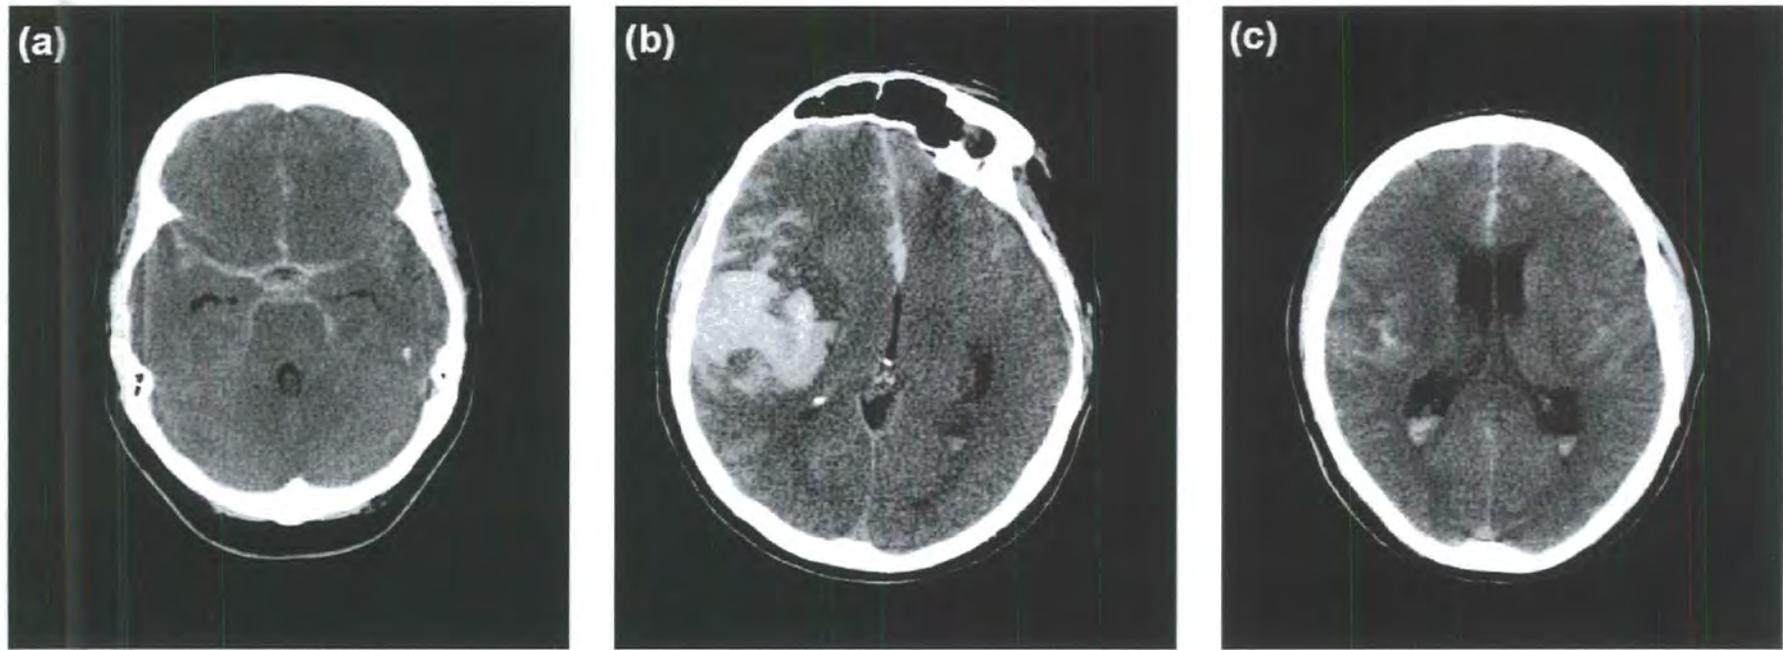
(a) Computed tomographic (CT) scan showing diffuse subarachnoid blood (basal cisterns; Sylvian fissures; anterior interhemispheric fissure) caused by ruptured left pericallosal aneurysm; (b) CT scan showing large temporoparietal intracerebral haematoma and extensive SAH caused by ruptured right middle cerebral artery aneurysm; (c) CT scan showing intraventricular blood and subarachnoid blood in interhemispheric fissure from rupture of an anterior-communicating artery aneurysm.
